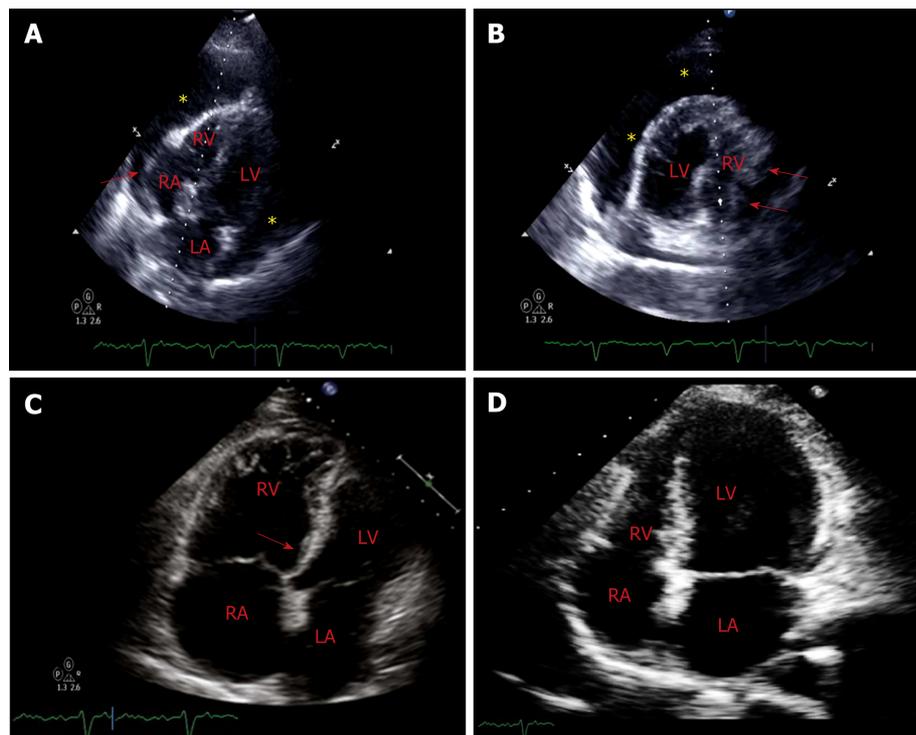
Computed tomography. A: Off-axis 4-chamber view of transthoracic echocardiogram demonstrates a large circumferential pericardial effusion (marked by *) with evidence of end diastolic right chamber compression (marked by red arrow) and normal left ventricular ejection fraction. Swinging heart sign was also noted which is used to describe pendular swinging of the heart inside the pericardial space and is associated with a large pericardial effusion; B: 4-chamber view (mirror-view) demonstrates RA inversion, RV diastolic compression (marked by red arrows) and the swinging heart sign; C: Limited surface echocardiogram after pericardiocentesis demonstrated interval resolution of pericardial effusion and mild to moderately dilated right ventricle with mild RV hypokinesis and septal shift towards the left ventricle (as marked by red arrow). Patient demonstrated paradoxical worsening of blood pressure. Rapid pericardial fluid decompression may have resulted in paradoxical worsening of hemodynamics likely secondary to a combination of two factors: the first being a sudden increase in the venous return with still relatively higher systemic vascular resistance posing to a preload-afterload mismatch (hemodynamic hypothesis) and secondly likely being focal RV hypokinesis, predisposed by an increased sympathetic tone; D: A repeat echocardiogram on day 5 demonstrated normalized ventricular function. RV: Right ventricular; LV: Left ventricular; RA: Right atrial; LA: Left atrial.
